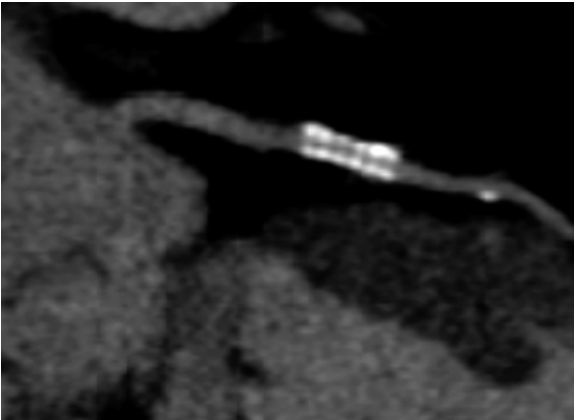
A 3.0-mm diameter stent in the LAD, imaged with contrast-enhanced 16-slice CT. Visualization of the in-stent lumen is compromised due to blooming artifacts
